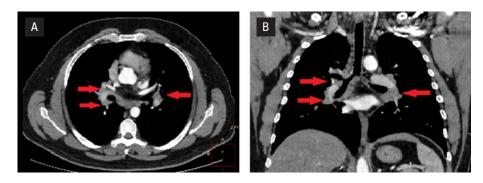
Computed tomography (CT) scans showing enlarged mediastinal lymph nodes after laparoscopic adrenalectomy.* A. *Transverse plane;* B. *Coronal plane*
